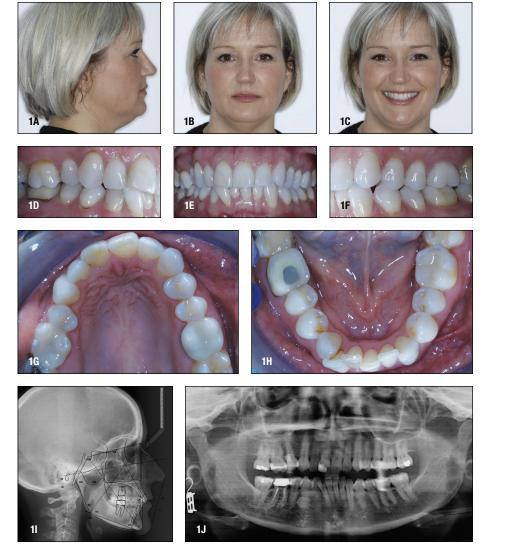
Pretreatment photographs, panoramic and cephalometric radiographs.
